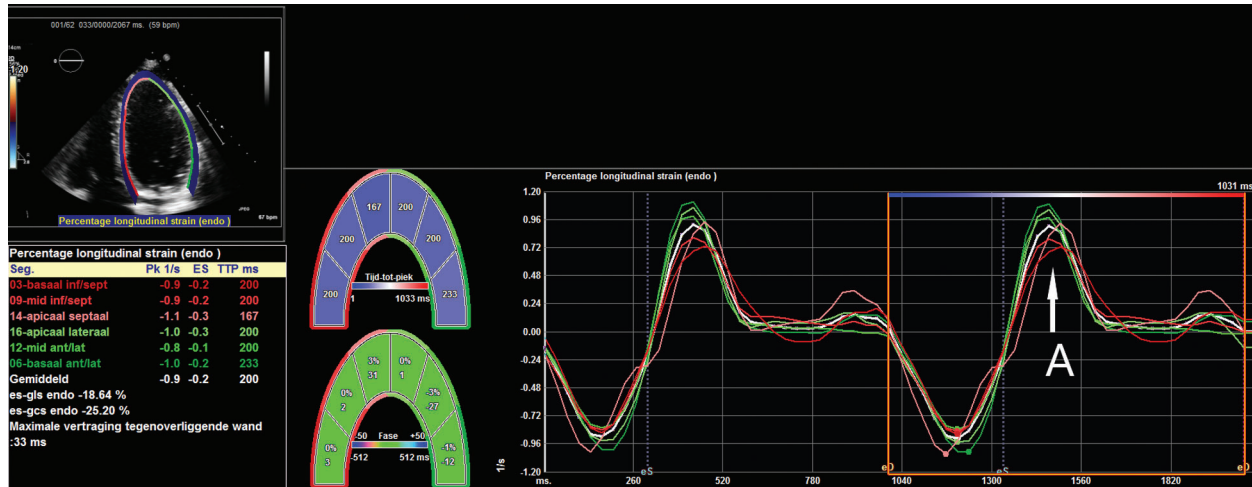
An example of strain analysis, where the apical four-chamber view has been used to analyze longitudinal strain and strain rate. The graph shows strain rate during the cardiac cycle; the peak at the arrow A represents the speed of early diastolic lengthening of the myocardium
